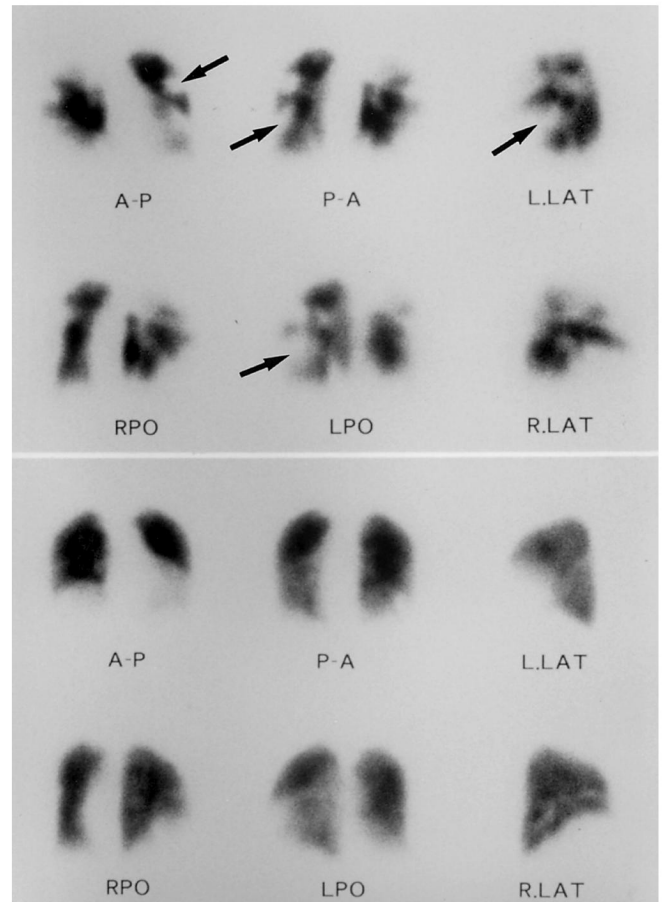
A 99m Tc-MAA Pulmonary blood flow scintigram after 5 hours revealed wedge-shaped multiple perfusion defects of bilateral lung (arrows) [top]. A pulmonary blood flow scintigram taken three months after treatment, showing the remarkable improvement of the perfusion defect. [bottom]. (A-P : antero-posterior, LPO : left posterior oblique RPO : right posterior oblique, LAT: lateral)
